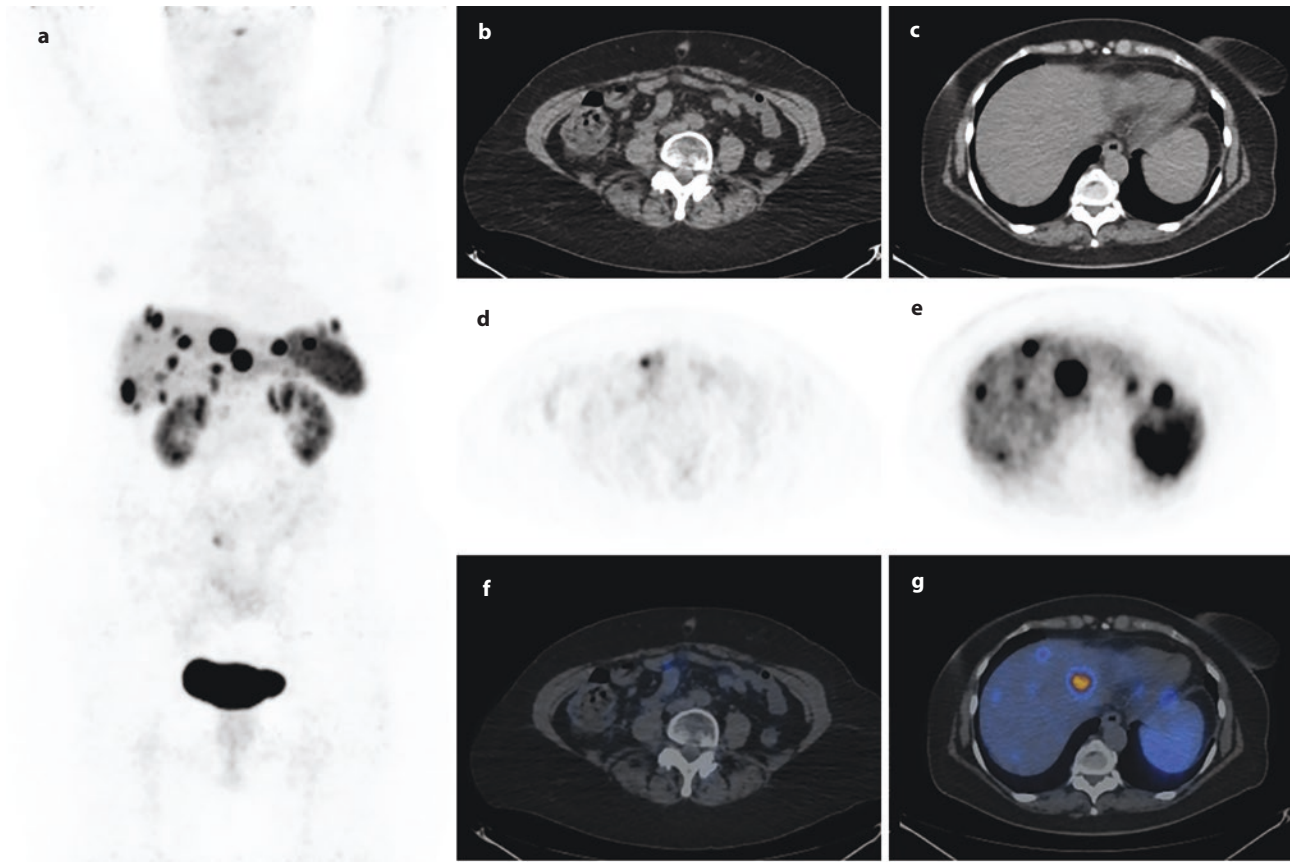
PET/CT MIP a, low dose CT b, c, PET d, e and fused PET/CT f, g transaxial images of a patient with multiple metastatic liver NEN lesions e, g and ileal primary d, f. All lesions show high
